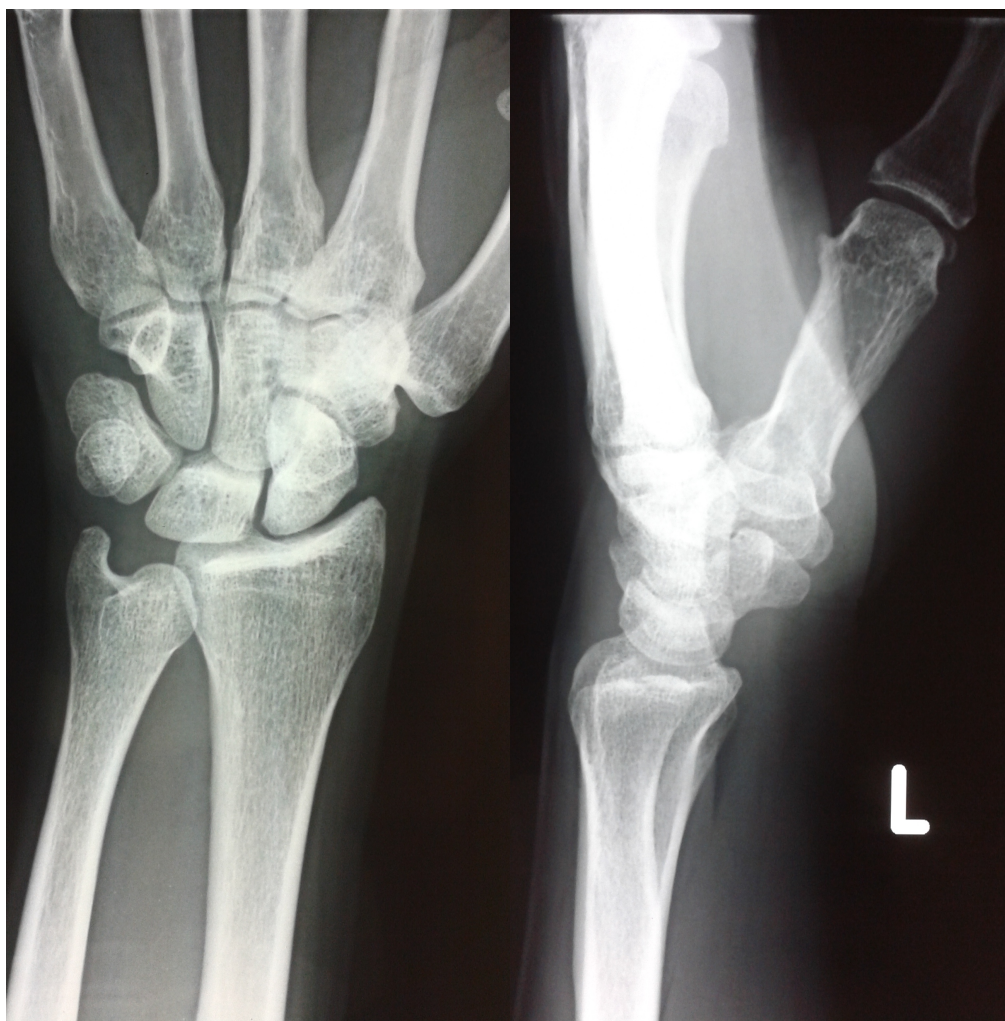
Posteroanterior and lateral radiographs of the distal radius (52)
